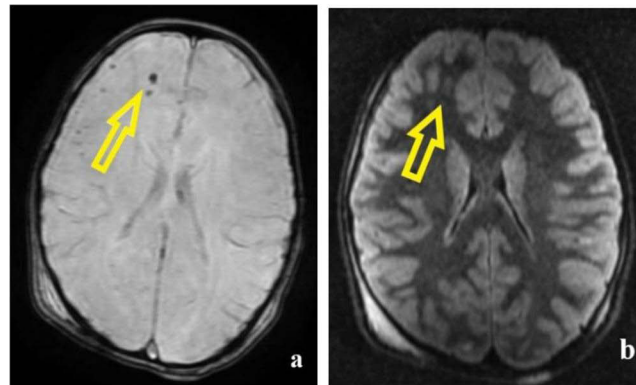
8-year-old girl, pedestrian involved in a motor vehicle accident. (a) In the white matter of the right frontal lobe- SWI and FLAIR imaging show small areas of low SWI signal (yellow arrow). (b) high FLAIR signal, consistent with frontal haemorrhagic DAIs (yellow arrow).
